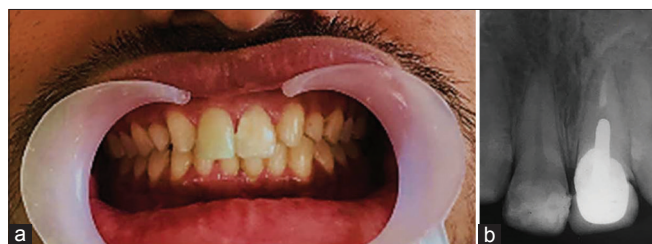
(a) Post-operative clinical photograph and (b) post-operative radiograph
